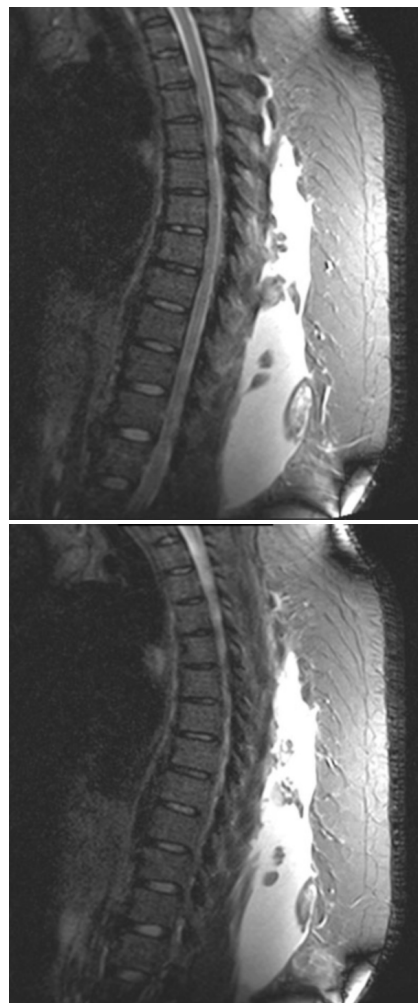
Two adjacent sagittal STIR MR images show a large fluid collection in the posterior subcutaneous fat tracking along the deep fascia at midline that represents a hematoma. It measures approximately 3.2 (anteroposterior) x 22.6 (craniocaudal) x 7.7 (transverse) cm. It extends from approximately T4 to T12-L1. There is avulsion of the trapezius muscles from the T3-T9 spinous processes, with fragments of torn muscle visible within the fluid collection.
